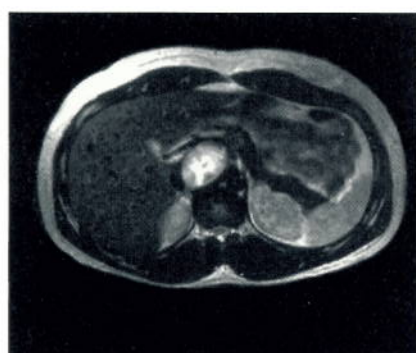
T2-weighted image demonstrates a large pheochromocytoma involving the right adrenal gland. (Courtesy of Boca Raton Community Hospital)
